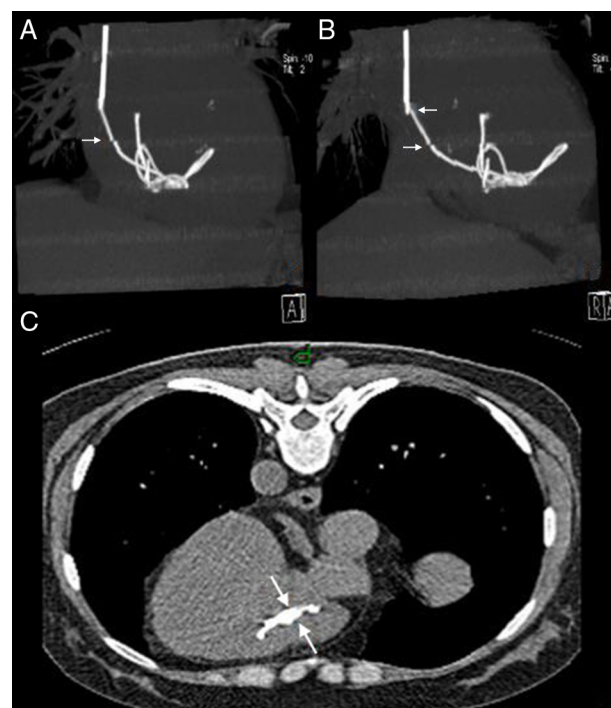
Thoracic computed tomography. (A) and (B) Dense, elongated image extending from the right atrium to the right ventricle, ending in tangled loops within the ventricular chamber, and apparent fragmentation (arrows); (C) control exam after removal of the catheter, showing what appears to be an intracardiac fragment (arrows).
